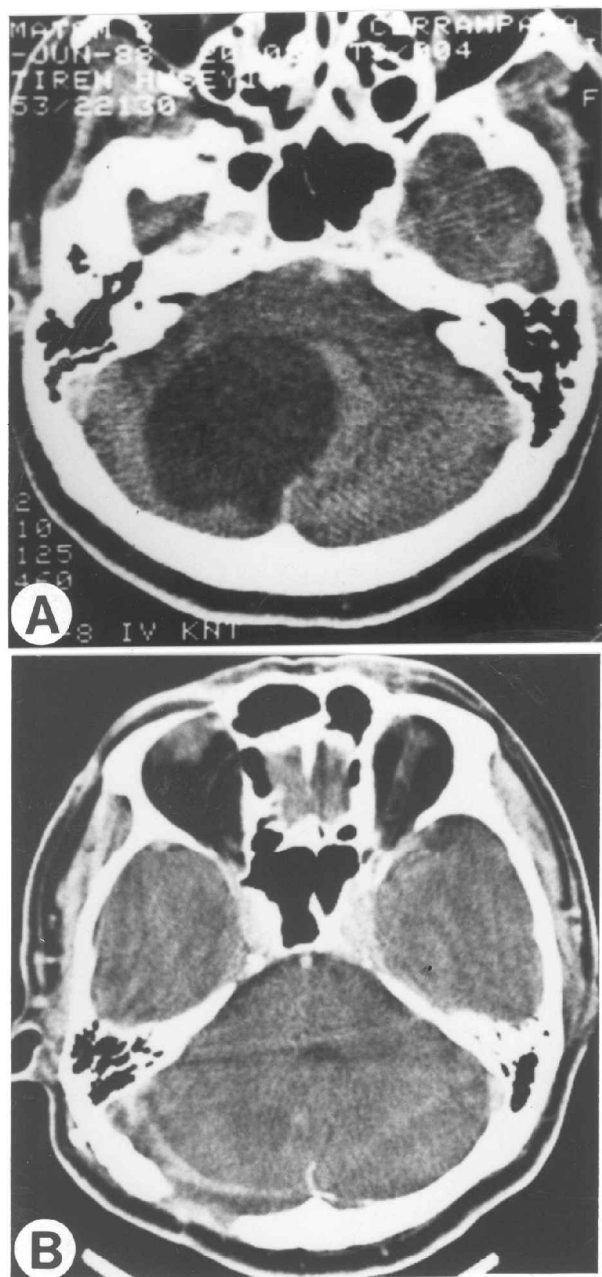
(A) Preoperative CT scan with contrast of case 6 shows an intracerebellar arachnoid cyst compressing the 4th ventricle. (B) Six months after cyst wall excision, on postcontrast CT scans, the cyst has almost entirely disappeared and the fourth ventricle is now well visualized.
